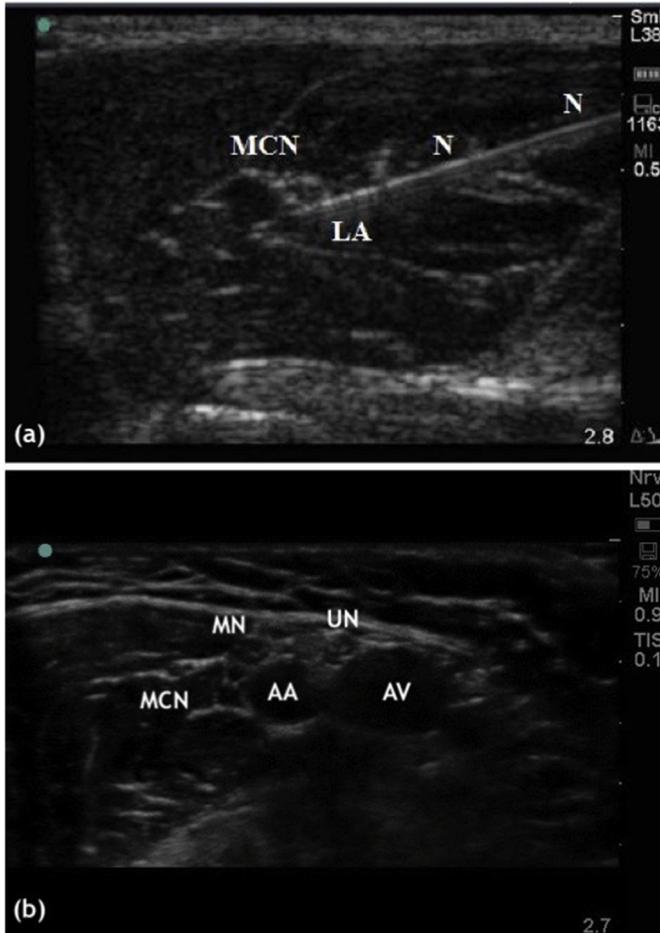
(a) Ultrasound image of the musculocutaneous nerve following injection of local anaesthetic obtained using a SonoSite Titan unit (SonoSite®, Bothwell, WA, USA) with a 38 mm high-frequency (7–10 MHz) linear array transducer (L38). Image taken by the author in 2006. MCN = Musculocutaneous Nerve; N = Needle; LA = Local Anaesthetic. (b) Ultrasound image of the axillary brachial plexus obtained using a SonoSite S-Nerve unit (SonoSite®, Bothwell, WA, USA) with a 38 mm high-frequency (10–13 MHz) linear array transducer (L38). Image taken by the author in 2013. MCN = Musculocutaneous Nerve; MN = Median Nerve Complex; UN = Ulnar Nerve; AA = Axillary Artery; AV = Axillary Vein.
